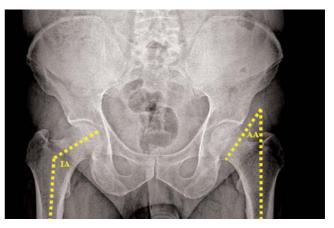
The inclination (IA) and Alsberg angle (AA) of the proximal femur measurements in radiography.
